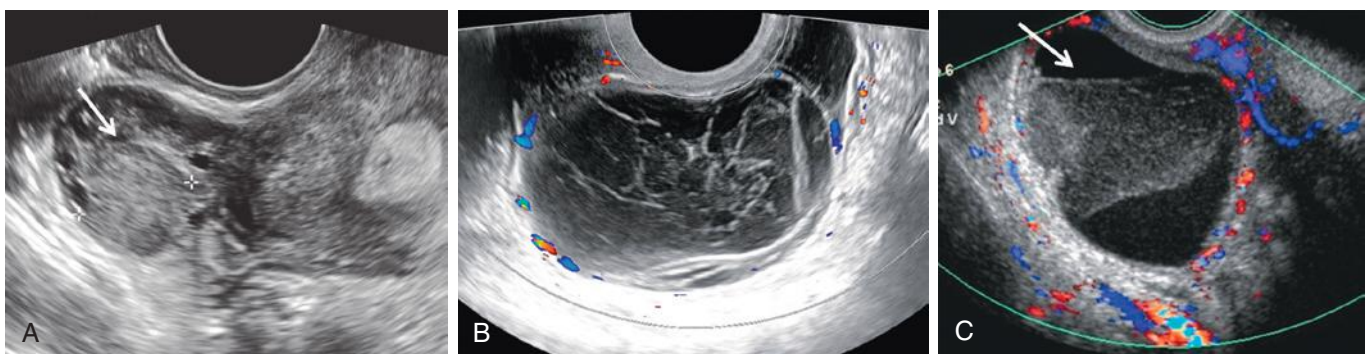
Sonographic spectrum of hemorrhagic ovarian cysts. A, Acute hemorrhage may appear as a solid lesion (*arrow* and *calipers*) with homogeneous low-level echoes. B, Typical fishnet or lace-like appearance representing fibrin strands. No internal vascularity is demonstrated with color Doppler sonography although vascularity is noted in the wall of the cyst. C, Retractable clot (*arrow*) possibly mimicking a solid nodule but recognized as a clot due to straight margins, acute angles, and lack of internal blood flow. Blood flow is shown in the wall of the cyst.
